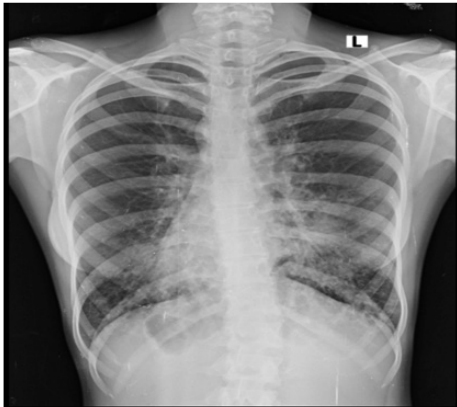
Chest X-ray (PA view) showing dextrocardia, with aortic arch and fundal gas shadow on the right side with bilateral prominent bronchopulmonary markings.
